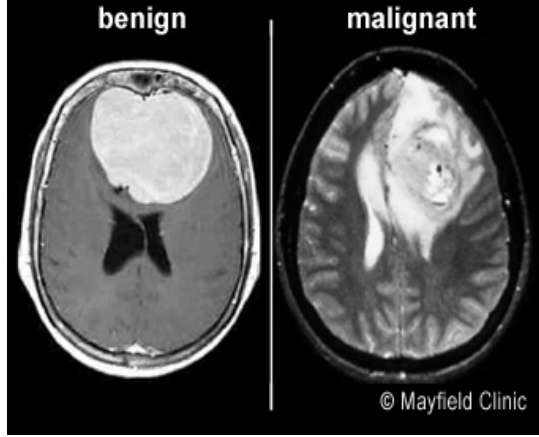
MRI scan of benign and malignant brain tumors
